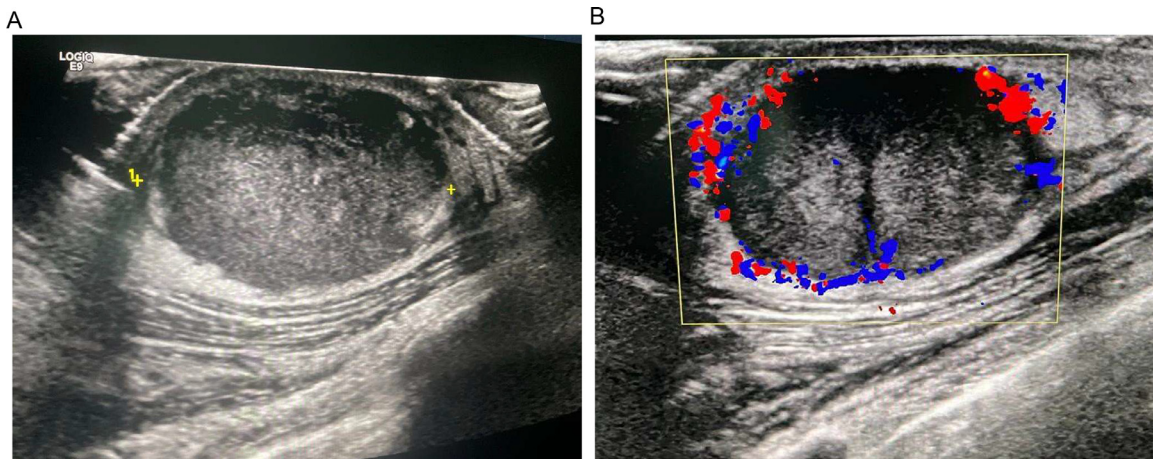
(A) Ultrasound of the anterolateral thoracic nodule showing its heterogeneous hypoechoic appearance. (B) Doppler study of the anterolateral thoracic nodule showing peripheral vascularization.
